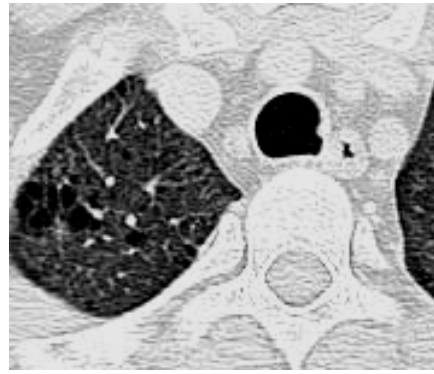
Axial CT, lung window at the level thoracic inlet shows small air filled cysts with tracheal outgrowths proved to be tracheobronchial papillomatosis.
